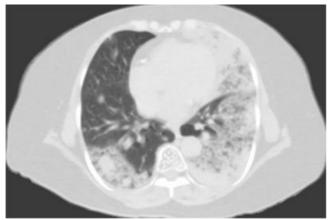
CT Thorax: showing bilateral ill defined air space opacities with adjacent ground glass opacities and air bronchograms within
